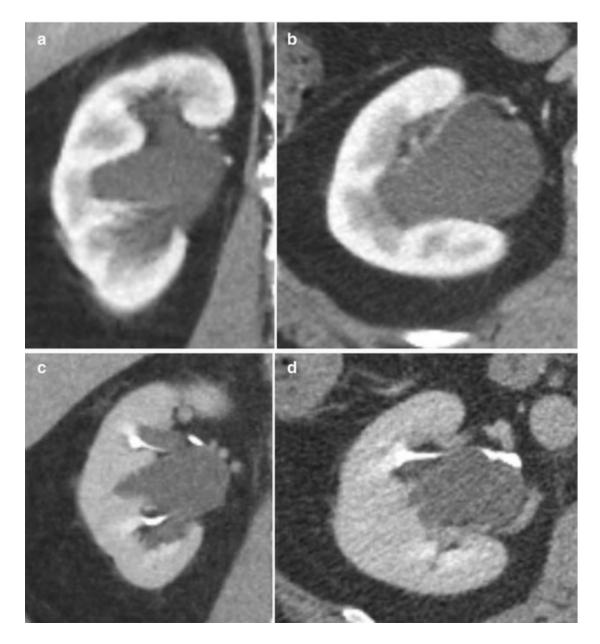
Incidental finding suggestive of hydronephrosis on contrast-enhanced abdominal CT in the corticomedullary phase, before iodine contrast material arrives in the collecting system (*upper row*: coronal (a) and axial (b) planes, respectively). Images obtained a few minutes later (in the excretory
